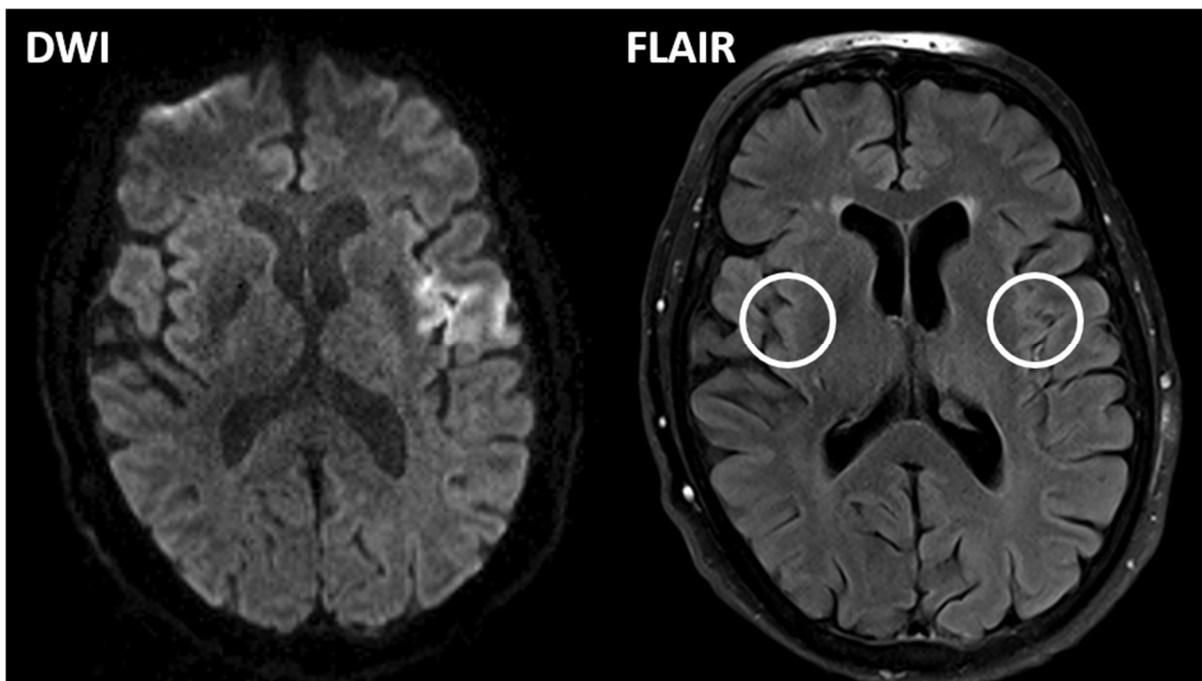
Using the example images from Figure 1, we visually identify the area on the FLAIR corresponding to the acute ischemic lesion on DWI and then place the ROI in the segment which we perceive as brightest (hot spot, shown here as white circle). The ROI is then duplicated and mirrored onto the contralateral hemisphere. The ratio between the signal intensity of the ROI on the infarcted side and the one on the unaffected side is calculated as rSI.
